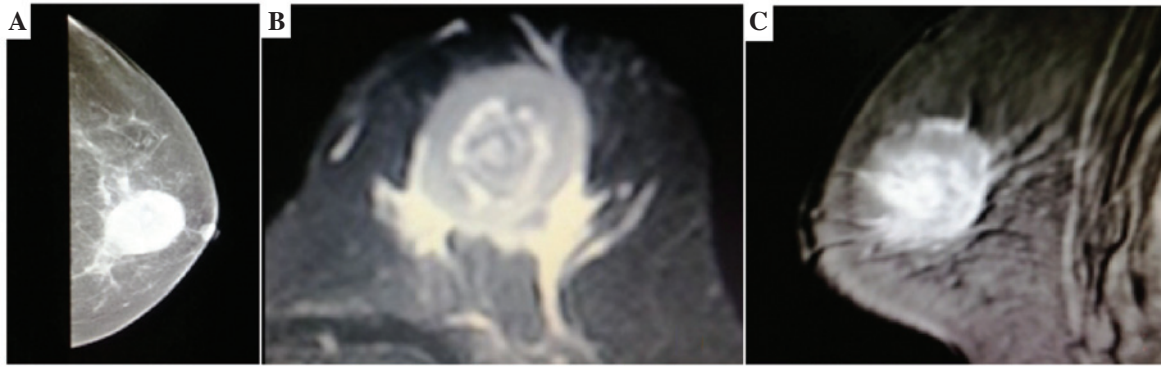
Mammography and T2-weighted coronal images. (A) Mammography showing a single, ill-defined, non-calcified mass in the left breast. (B and C) T2-weighted coronal images showing a single, ill-defined, inhomogeneous, hyperintense mass.
